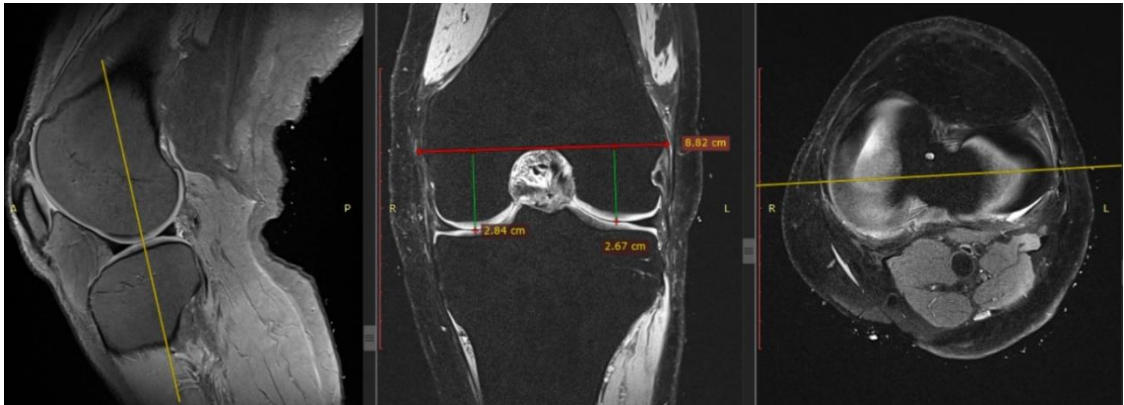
Example MRI images to obtain distance measurements and scanning reports on the bone, meniscus and cartilage condition prior to testing.
